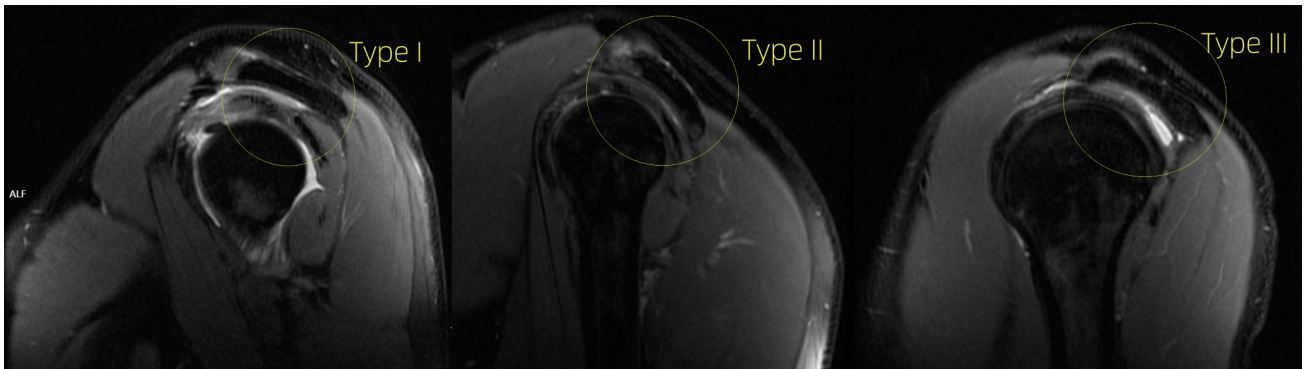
Three typical acromion shapes were observed on magnetic resonance imaging (MRI).
